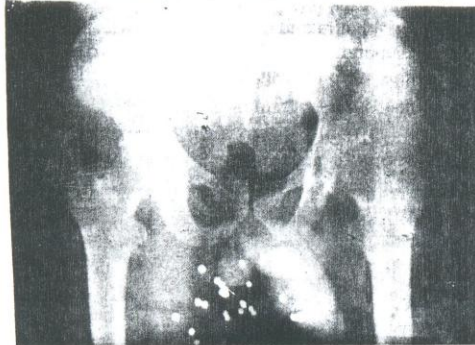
Radiograph showing 5 superficial pellets in the penis. All were removed at Surgery.
